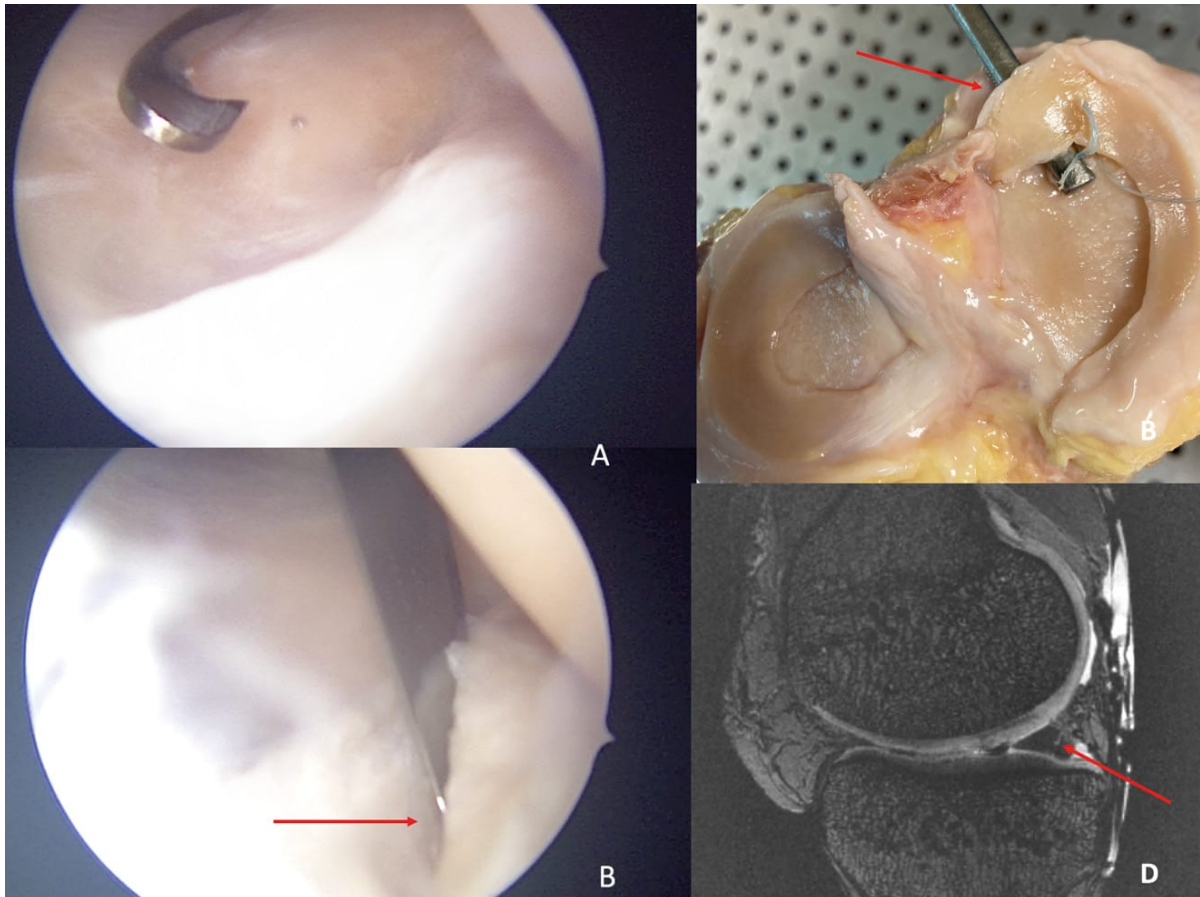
Arthroscopic views (A and B) of subtype 4 medial meniscus ramp lesion realization by a posteromedial approach. Open view of the knee and its meniscal ramp lesion injury after experimentation (C). MRI sagittal view in sequence T2 DESS of the subtype 4 ramp lesion injury.
